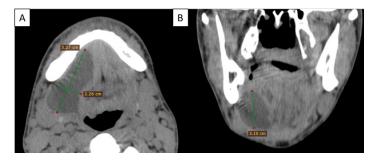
CT of head and neck. A: Axial view. B: Coronal view
